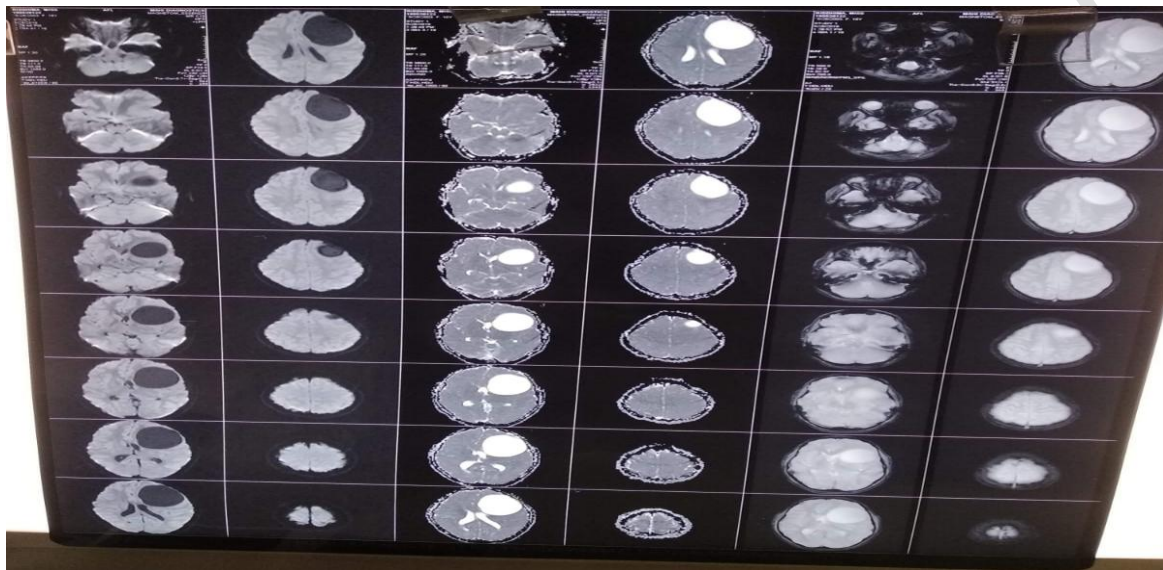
Preoperative Contrast enhanced magnetic resonance imaging of the space occupying lesion in the frontal lobe
